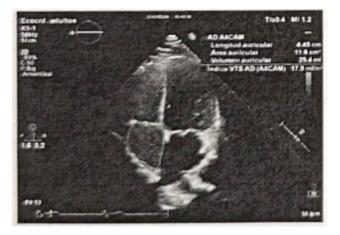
Apical four-chamber echocardiogram with parameters within the normal range. Criteria of decompensation and impairment of renal function were excluded, as well as the diagnosis of anxiety, major depression and suicidal risk by psychology (Table 2).
